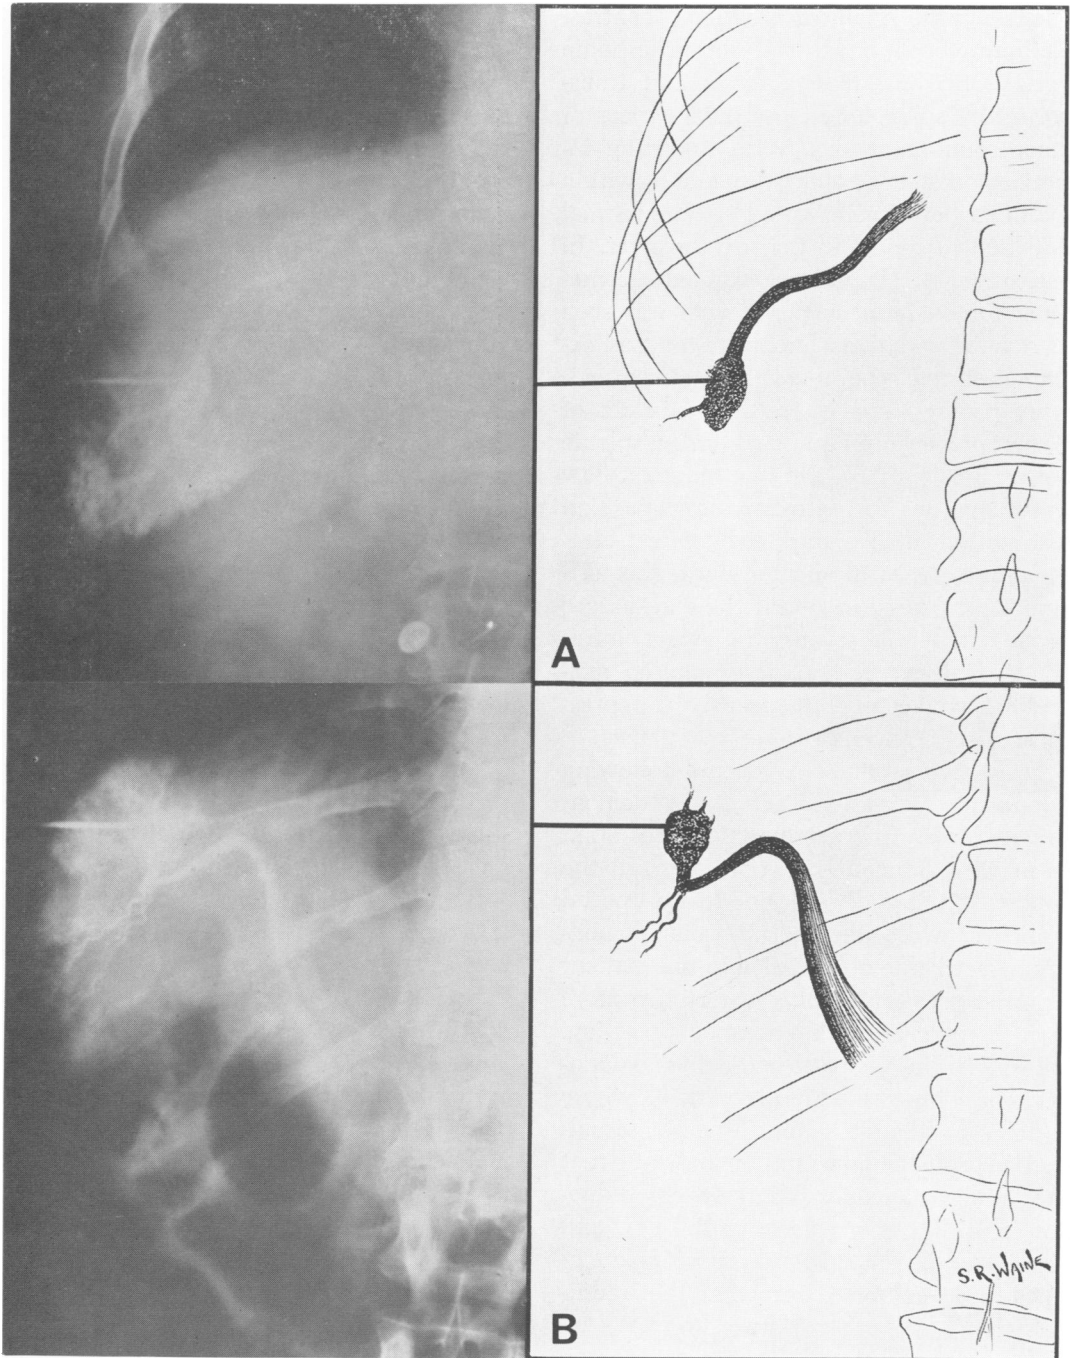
Radiographic demonstration of true reverse flow in the portal vein following a side-to-side shunt.
